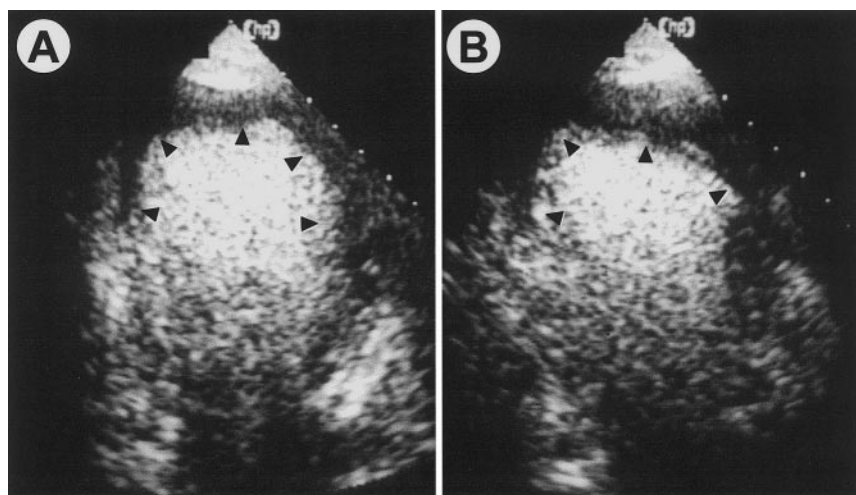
MCE at end systole (apical 2-chamber view) in patient with anterior AMI before PTCA (A) and at 24 hours (B). Sum of endocardial border length corresponding to risk region (arrows) in 2- and 4-chamber views was measured as 18.9 cm before PTCA and 17.0 cm after 24 hours ("no-reflow" region). Ratio to risk region of 90% despite recanalized infarct-related artery indicated poor myocardial reperfusion.
